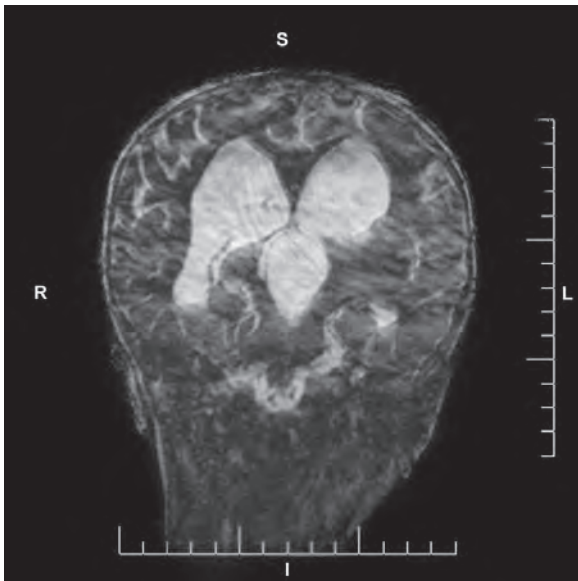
MRI of the brain, coronal T2W image in a patient with aqueductal stenosis
